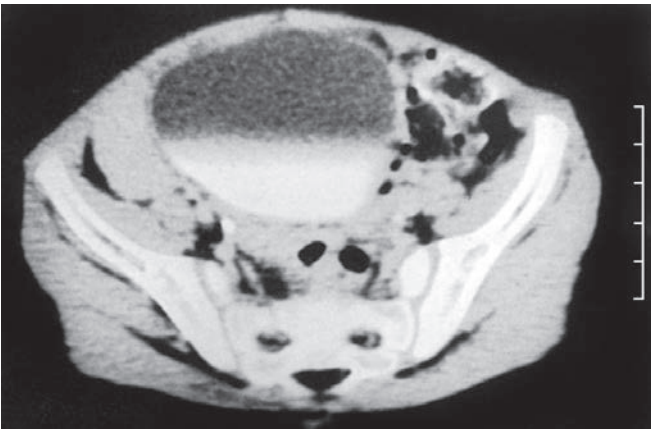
Pelvic CT scan after chemotherapy showing complete disappearance of the yolk sac tumour recurrence
